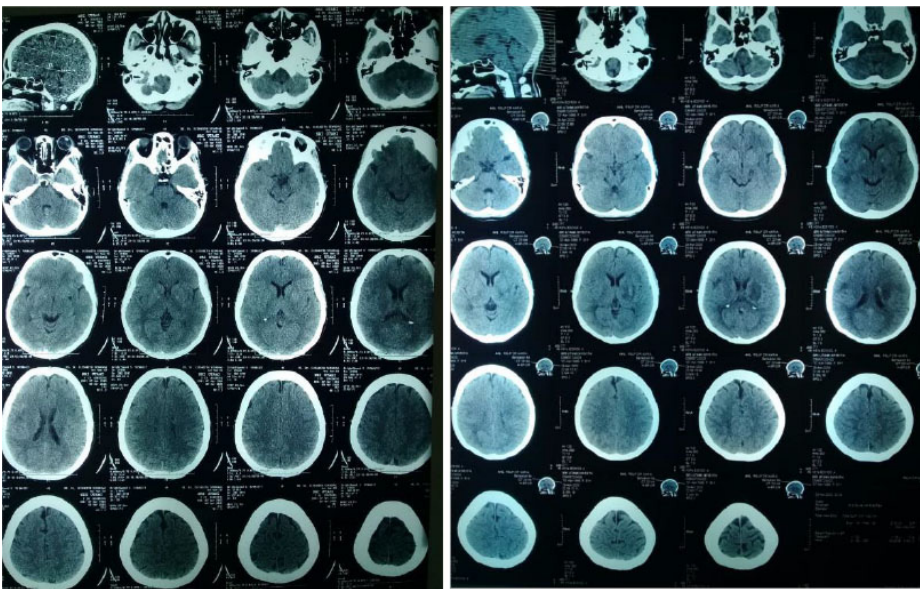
Non-contrast head CT Scan of patient 2 showing (a) left basal ganglia infarction; (b) hemorrhagic transformation on the site of left basal ganglia infarction with perifocal oedema and right frontal lobe infarction.
